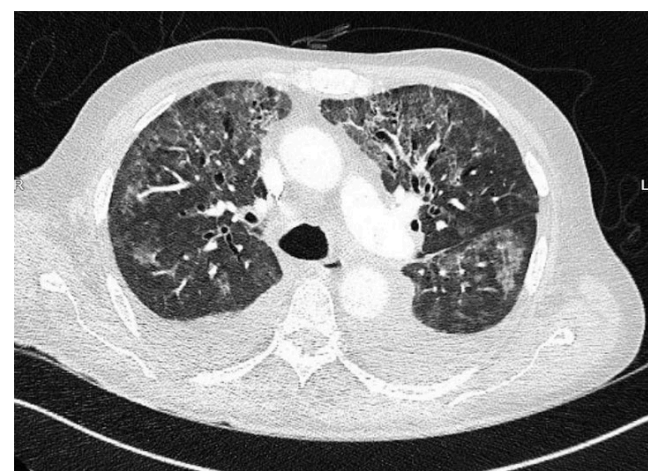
CT-scan of the thorax revealing bilateral, lobulated ground-glass opacities with early consolidation and pleural effusions
